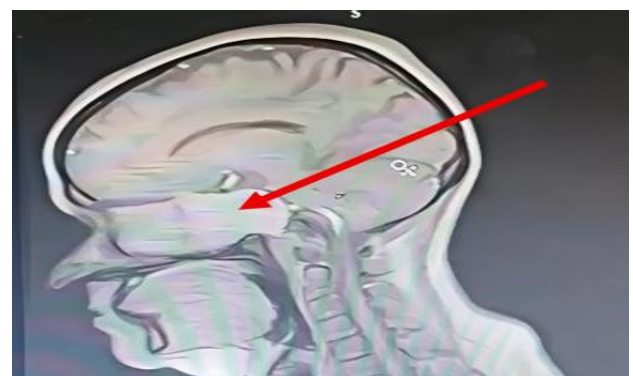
Sagittal MRI showing extra-dural extension into middle cranial fossae with preserved brain parenchyma (arrow indicates lesion boundary).
